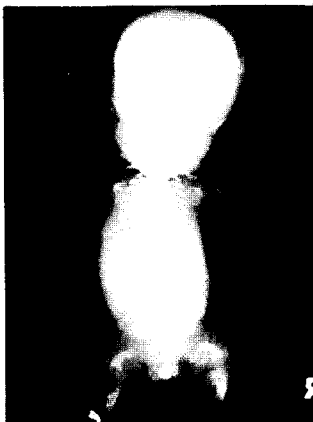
(Case II) Postnatal radiograph confirms the prenatal findings. (micromelia extremely shortened femurs, enlarged head, and flattened vertebral bodies; H-shape)
